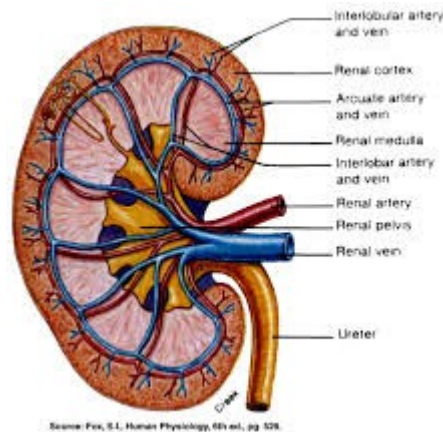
shown the structure of the kidney (Radiographic.rsna.org)
